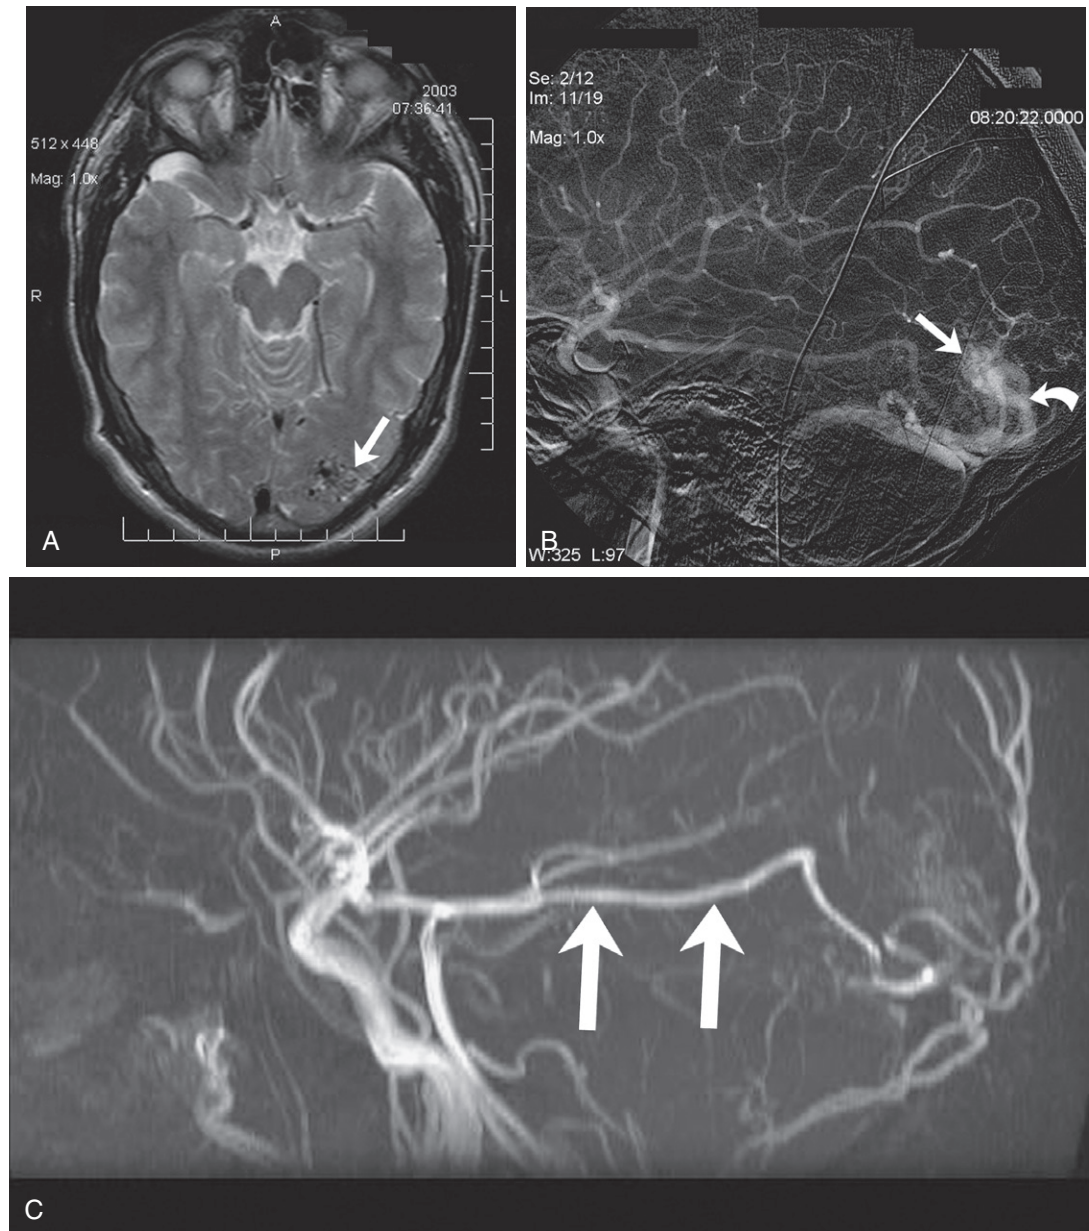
A 14-year-old child with a left occipital arteriovenous malformation (AVM). A, MRI shows multiple flow voids in the left occipital lobe (arrow). B, Lateral view from catheter angiogram confirms the presence of an AVM (arrow) and early draining veins (curved arrow). C, Lateral maximum intensity projection image from an MR angiogram shows an enlarged posterior cerebral artery branch (arrows), which feeds the tangle of abnormal vessels.
